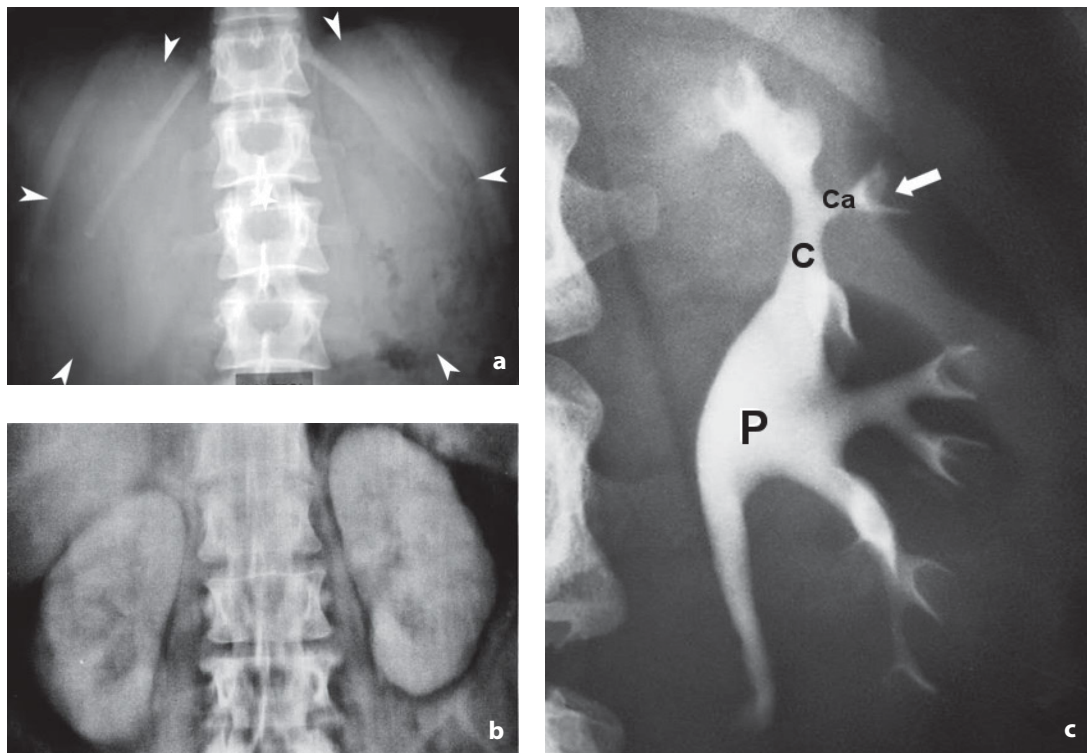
Urography. Kidney. a Plain film radiography. The kidneys (*arrowheads*) can be identified thanks to the natural contrast provided by the perirenal fat. b Nephrographic phase. The uniform enhancement provided by the contrast medium displays the morphology of the kidney. c Excretory phase. Detailed visualization of the pyelocaliceal cavities. The arrow indicates the papilla. C, major calix; Ca, minor calix; P, pelvis
